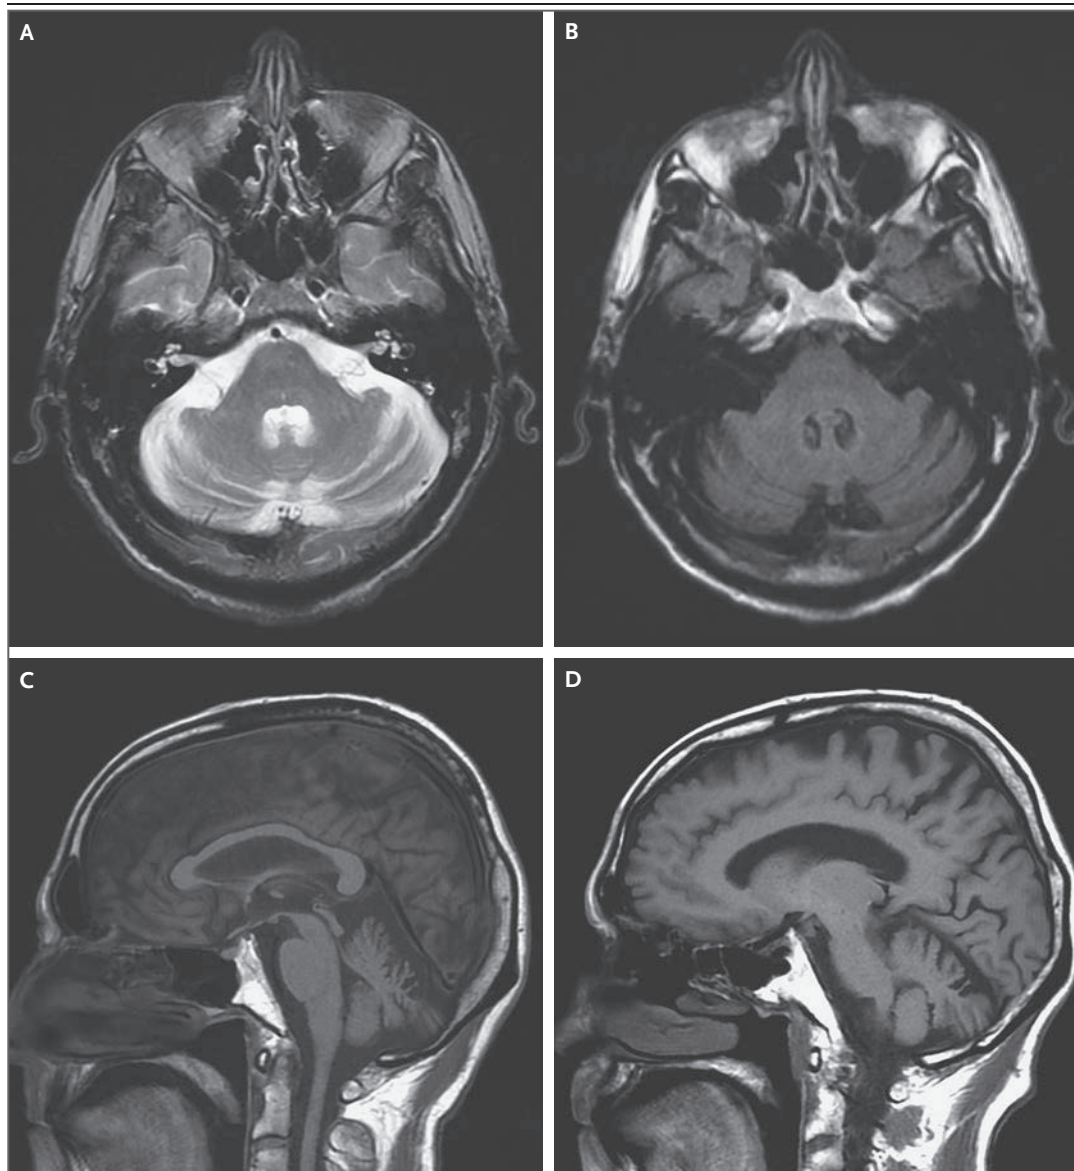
MRI of the Head.
